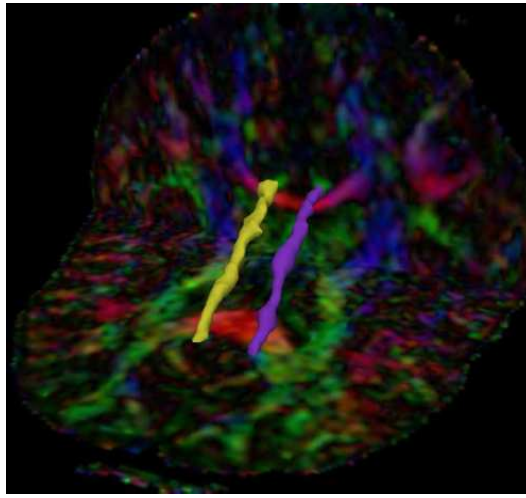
Result on DW-MRI data. The structures in yellow and magenta indicate the CB surface identified in the right and left hemisphere of the brain volume.
